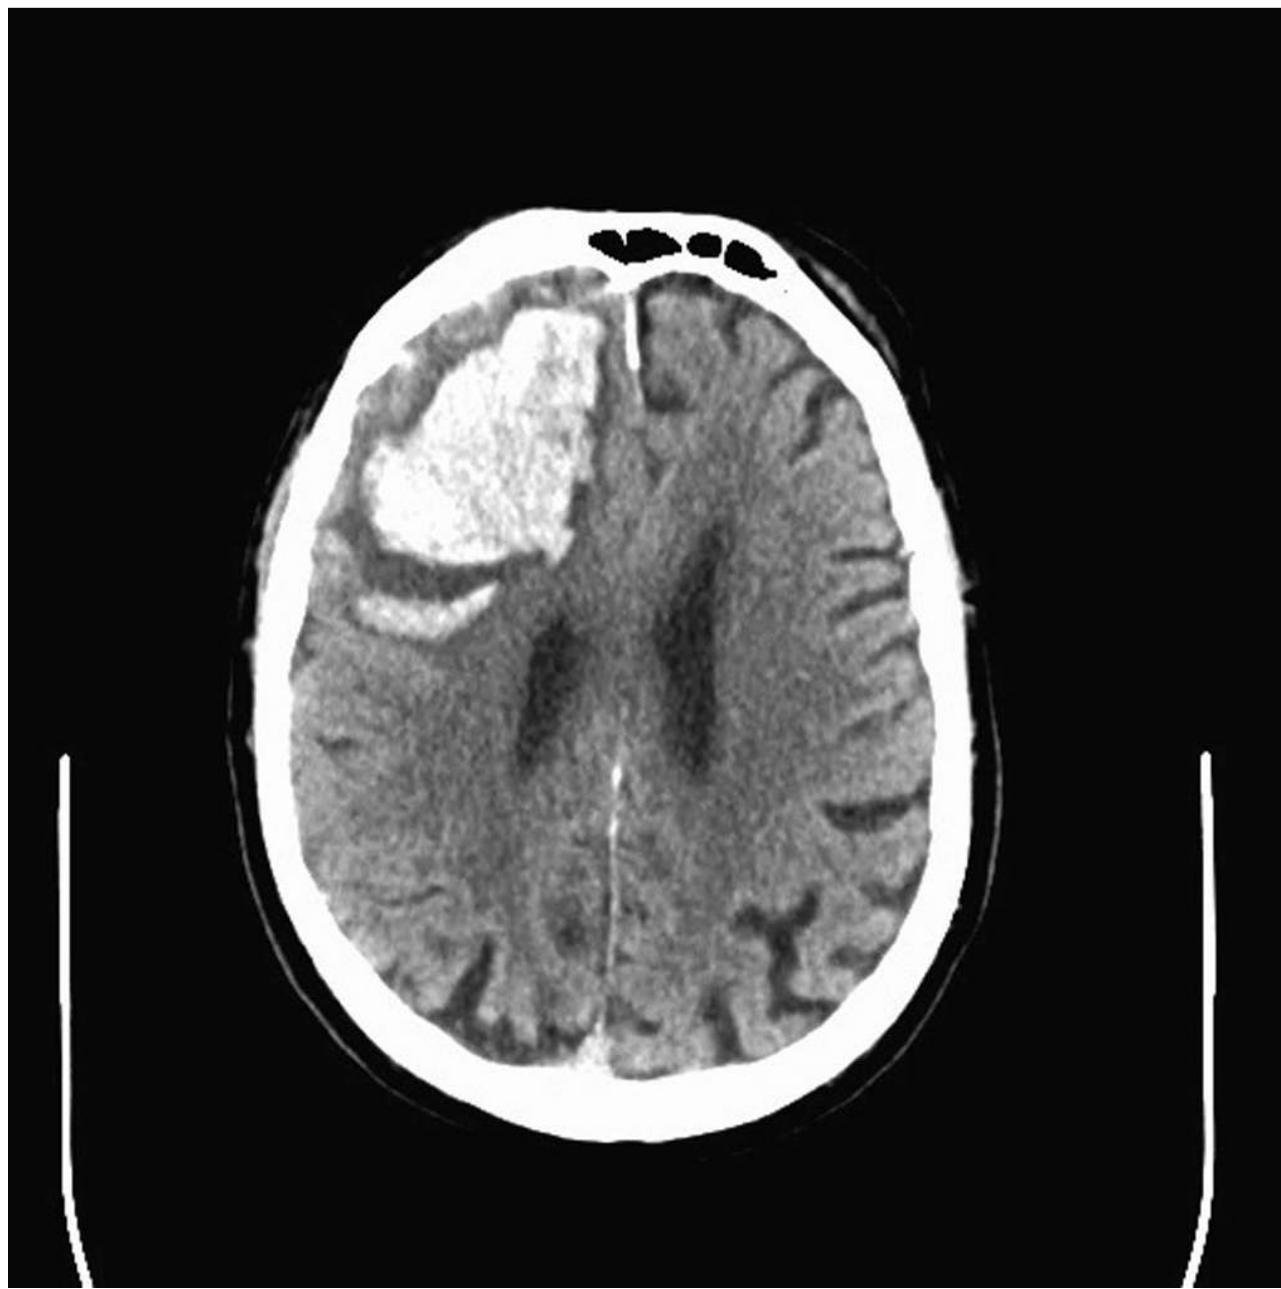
CT lobar hemorrhage. The patient presented with sudden-onset left-sided weakness with alteration of consciousness.
